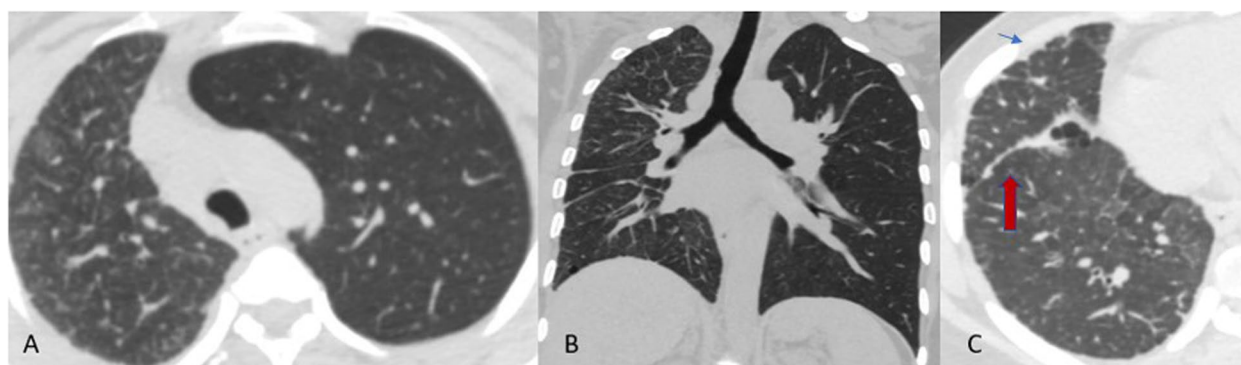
HRCT thorax (A-axial, B-coronal and C-axial) Lung window reveals small-sized right hemithorax, compensatory overinflation of left lung with mild mediastinal and tracheal shift towards right and elevation of right hemi diaphragm, thickening of right oblique fissure (marked by red arrow) and septal thickening (marked by small blue arrow) and centrilobular ground glass densities in right lung
